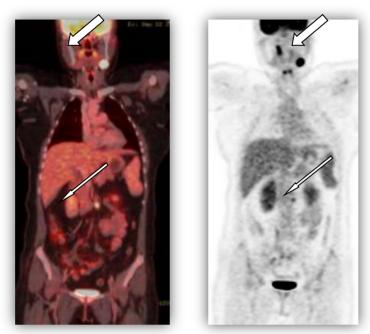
whole body sagittal fused PET/CT image Fig. 5d: axial fused PET/CT image of the lower abdomen
